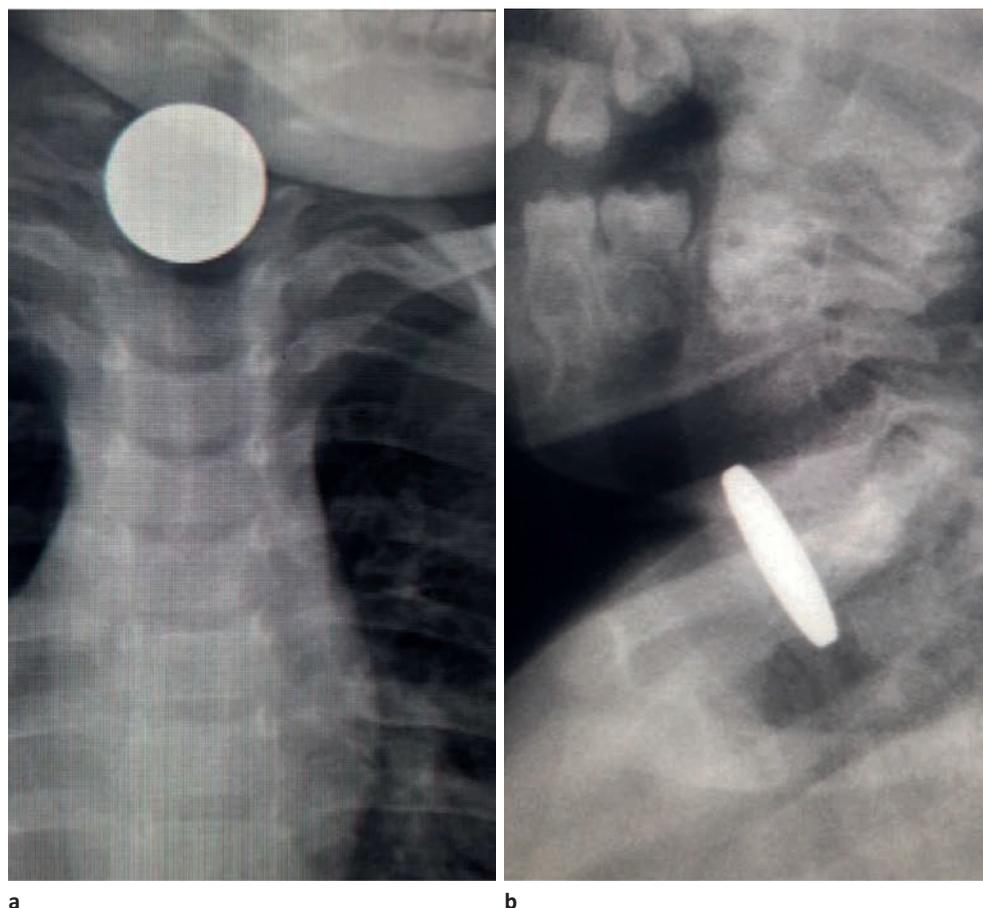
Plain (a) and lateral (b) X-ray of coin ingestion child ("Grigore Alexandrescu" Hospital Radiology Department Library)
